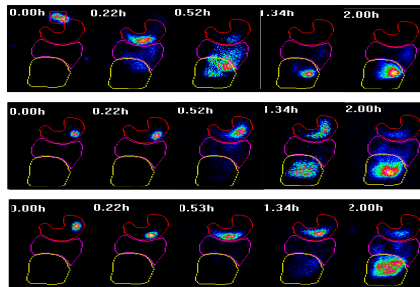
Abdominal gamma scintigraphy images of Subject 2 after administration of solution (top), tablet fasted (middle), tablet fed (bottom) from time 0 to 2 hr
